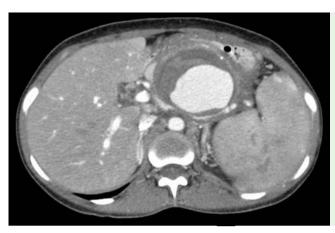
Computed tomography angiography showing a large splenic artery pseudoaneurysm.
